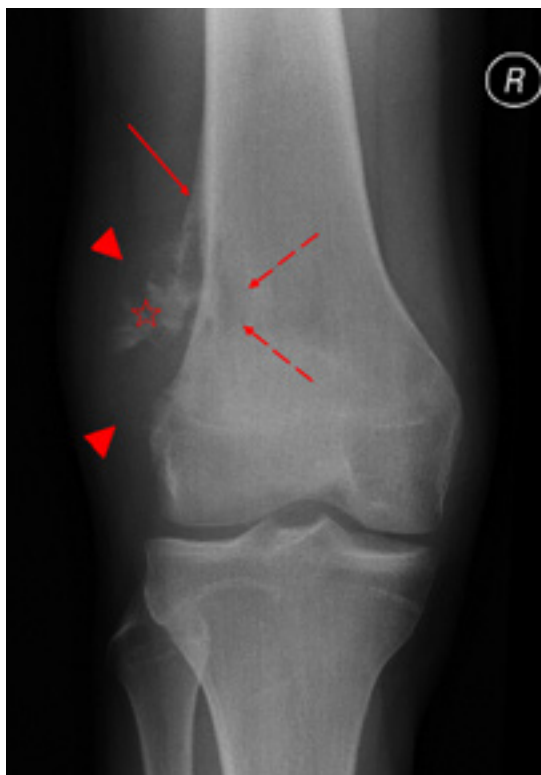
Anteroposterior radiograph of the right knee joint. Mixed lytic and sclerotic tumor in the distal metaphysis of the femur with radiographic characteristics of malignancy, i.e., detachment of the periosteum in the form of a Codman triangle (continuous arrow), a poorly defined area of osteolysis in the bone (dashed arrows), and the shadow of a periosteal tumor at the lateral side (arrowheads), with visible bone formation (asterisk) – initial examination
